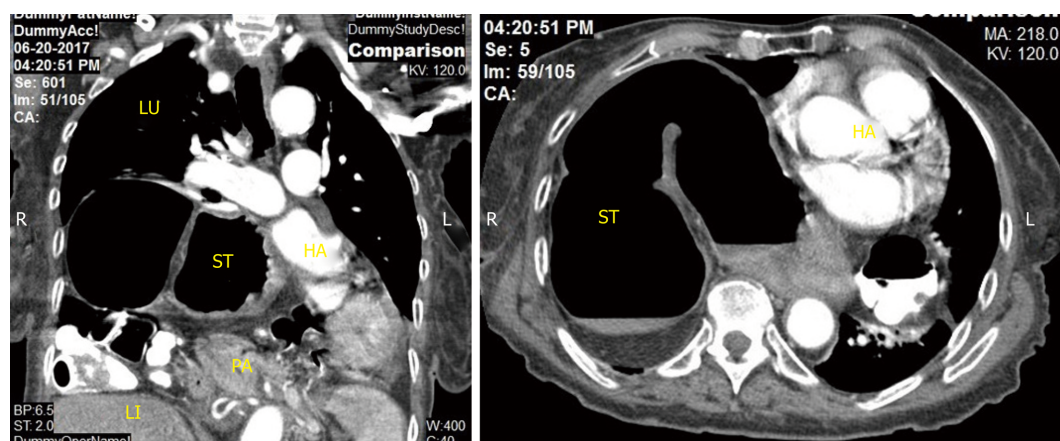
Demonstrate the computed tomography of the chest with large hiatal hernia. No pancreas in the hernia sac. ST: Stomach; LI: Large intestine; PA: Pancreas; HA: Heart; LU: Lung.
